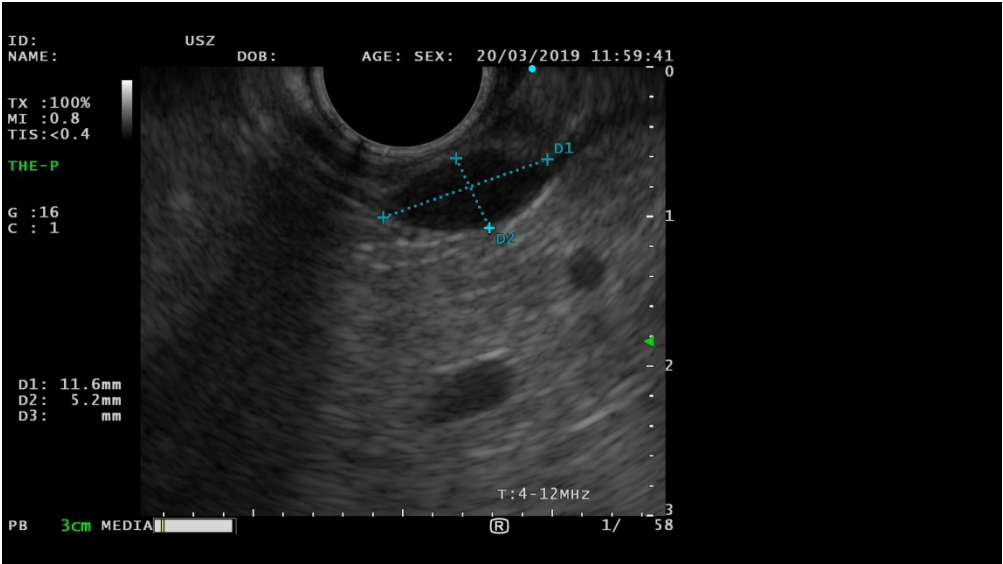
Endosonographic image of lesion
